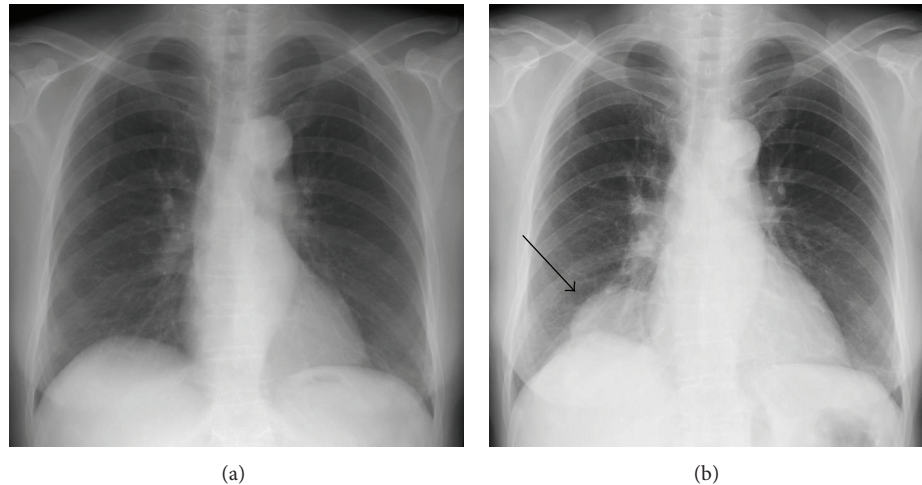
Chest X-ray at the onset of DM (a). Chest X-ray at the lung cancer diagnoses showing a tumor in the right lower lung field 5 years after the onset of DM (b).
